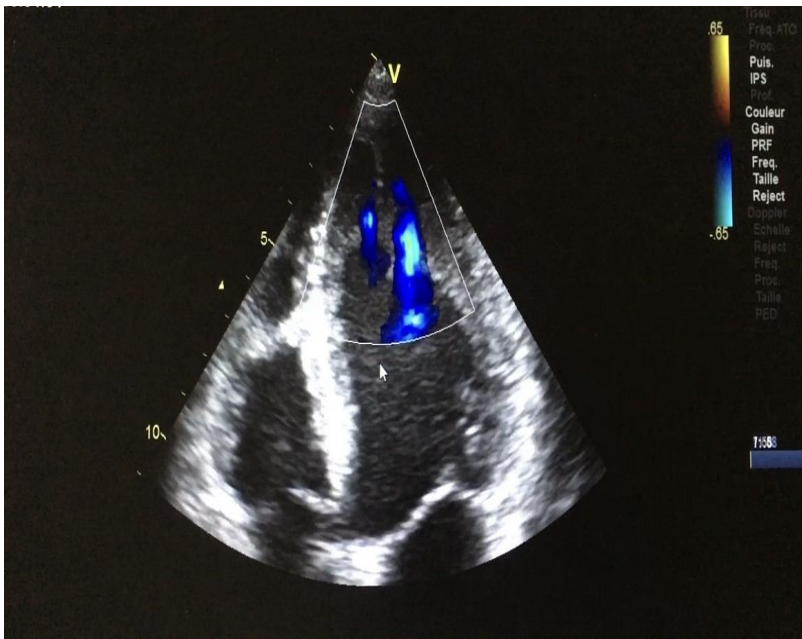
apical 4-chamber echocardiographic section showing inter trabecular recesses taking colour on colour doppler
